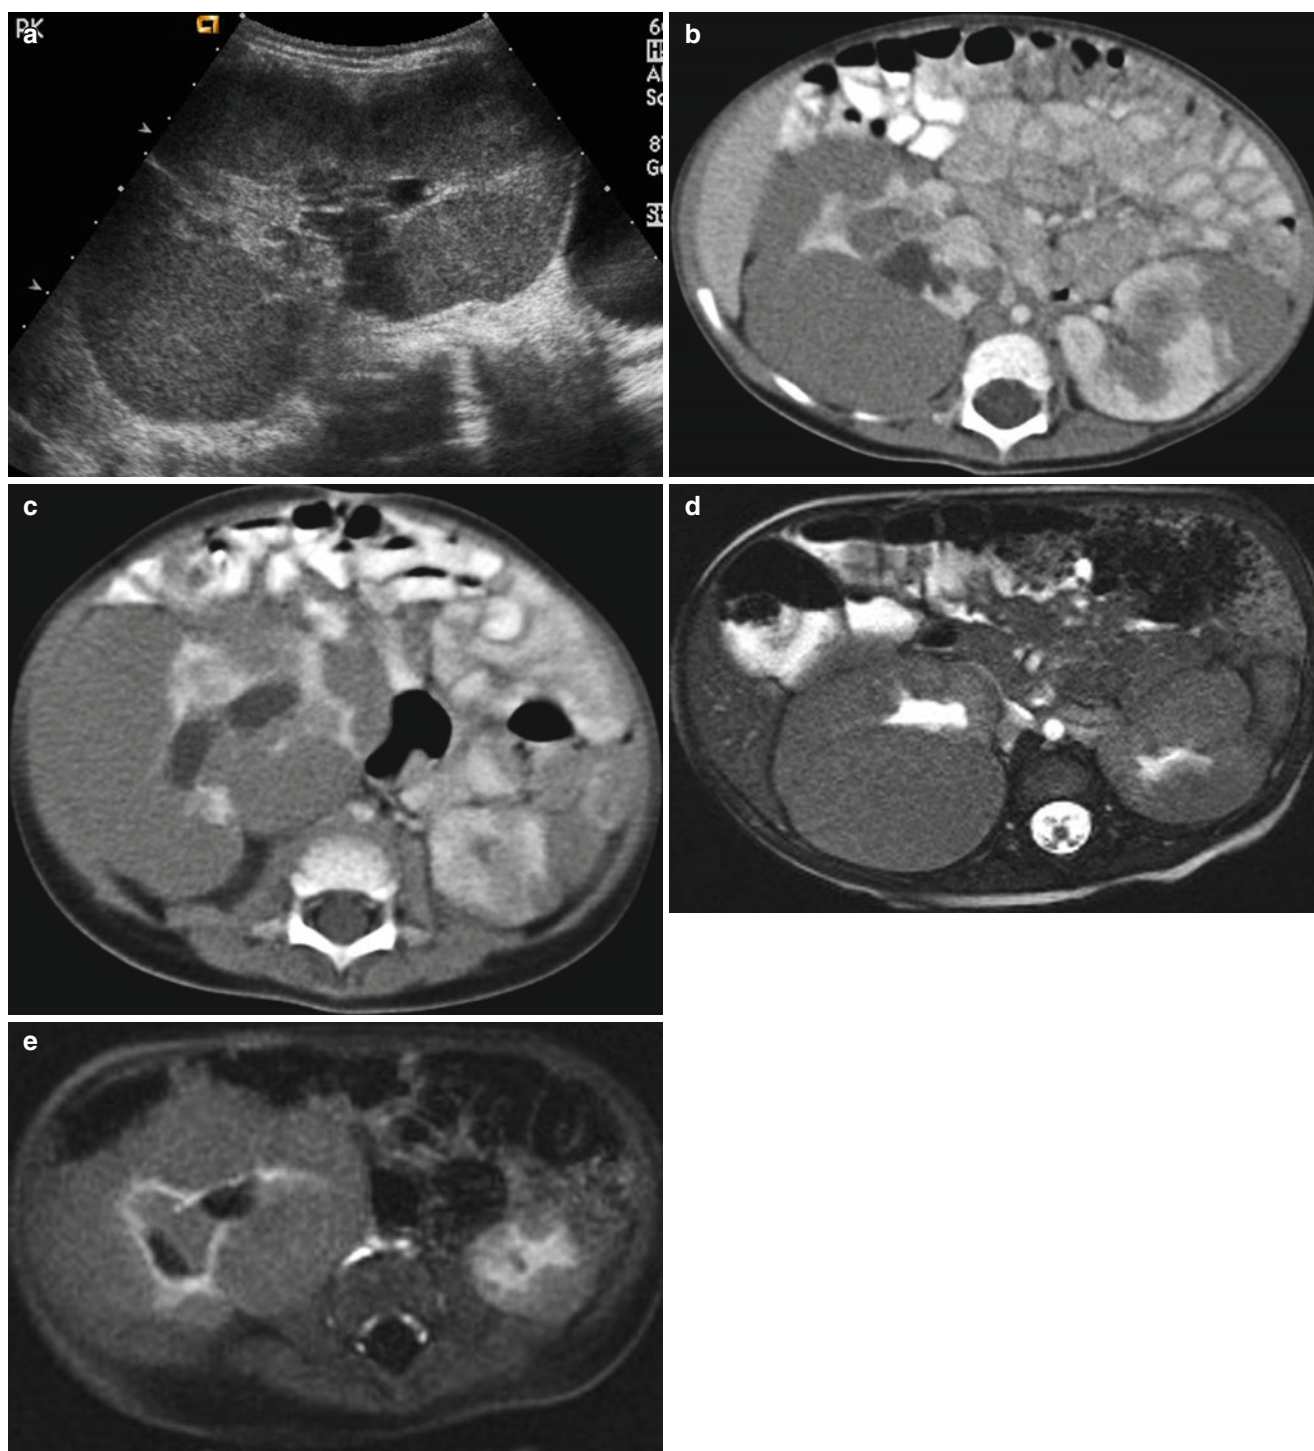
Nephroblastomatosis in a 6-year-old girl. (a) Longitudinal US shows an enlarged right kidney with lobulated contour and multiple homogeneous hypoechoic cortical masses. (b and c) Contrast-enhanced CT scans show multiple, round, peripheral masses of low attenuation.
